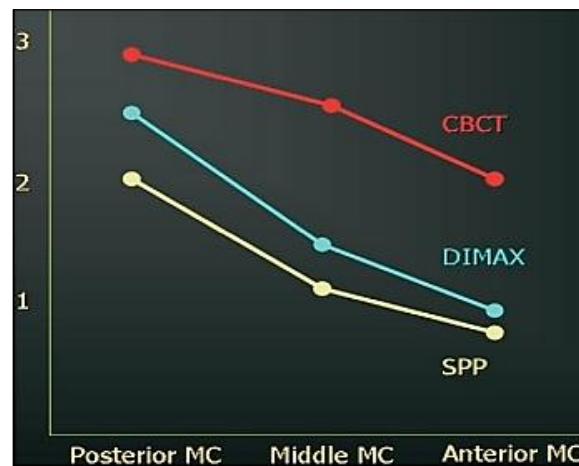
Graphic representation of performance of the 3 imaging modalities tested for the visualization of the mandibular canal (MC). The CBCT reformatted panoramic images depicted the mandibular canal better than digital panoramic radiographs did. It is also clear that the posterior third of the mandibular canal was better visualized, regardless of modality
